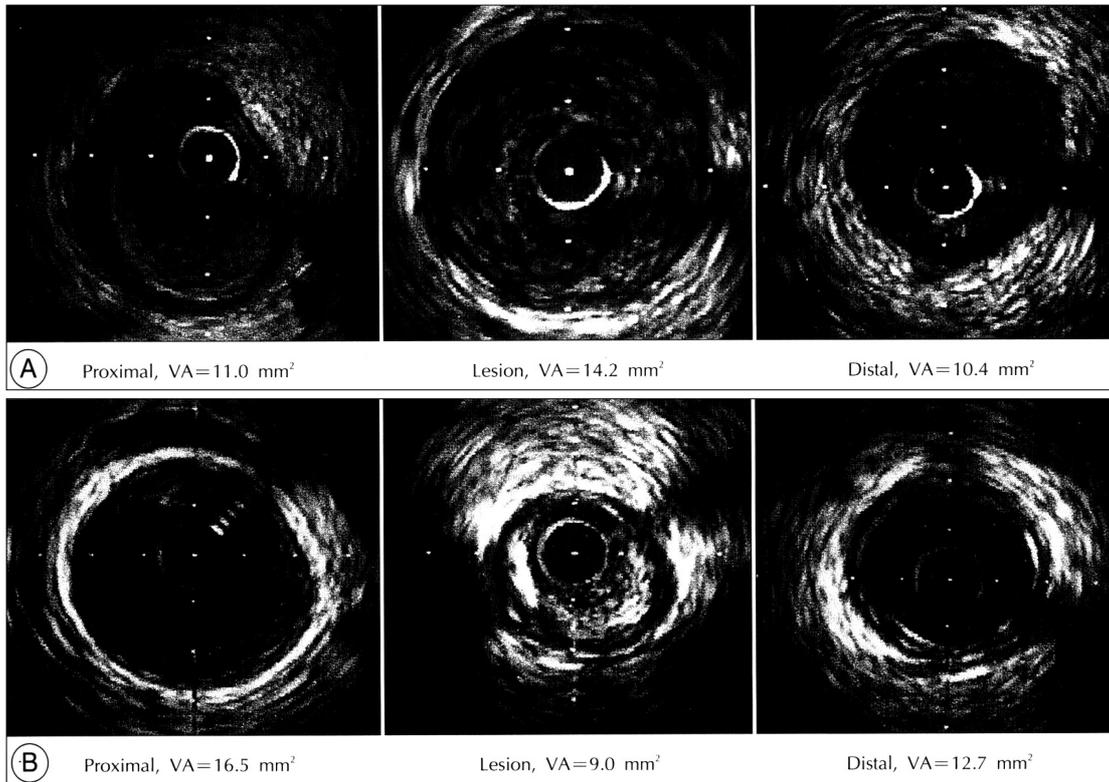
A : Intravascular ultrasound images at the proximal, lesion, and distal measurement sites of a vessel with compensatory remodeling and a soft plaque. The vessel area (VA) was larger at the lesion site than at the proximal and distal reference sites. Remodeling index was 1.29. B : Intravascular ultrasound images at the proximal, lesion, and distal measurement sites of a vessel with constrictive remodeling and a hard plaque. VA was smaller at the lesion site than at the proximal and distal reference sites. Remodeling index was 0.55.
